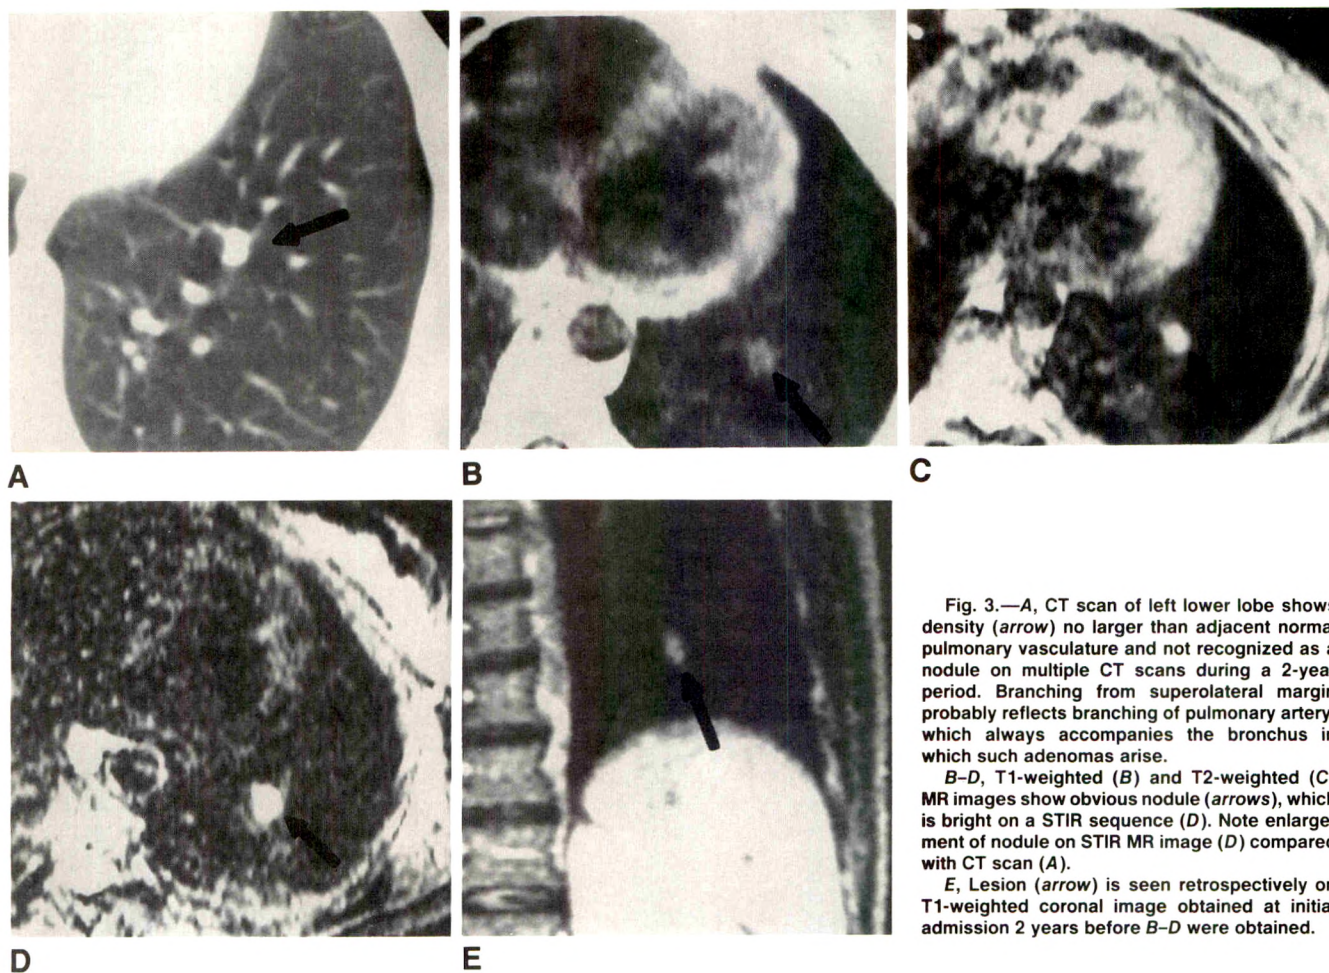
A, CT scan of left lower lobe shows density (arrow) no larger than adjacent normal pulmonary vasculature and not recognized as a nodule on multiple CT scans during a 2-year period. Branching from superolateral margin probably reflects branching of pulmonary artery, which always accompanies the bronchus in which such adenomas arise.
